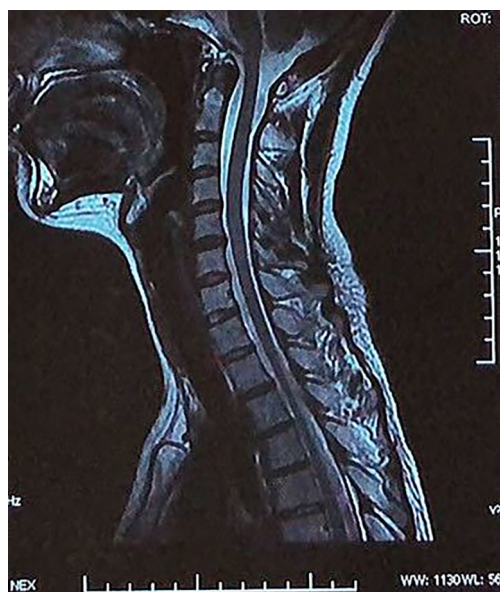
The magnetic resonance imaging scans of case 2 show a large central herniation of the C5/6 disc with signs of mild spinal compression.
